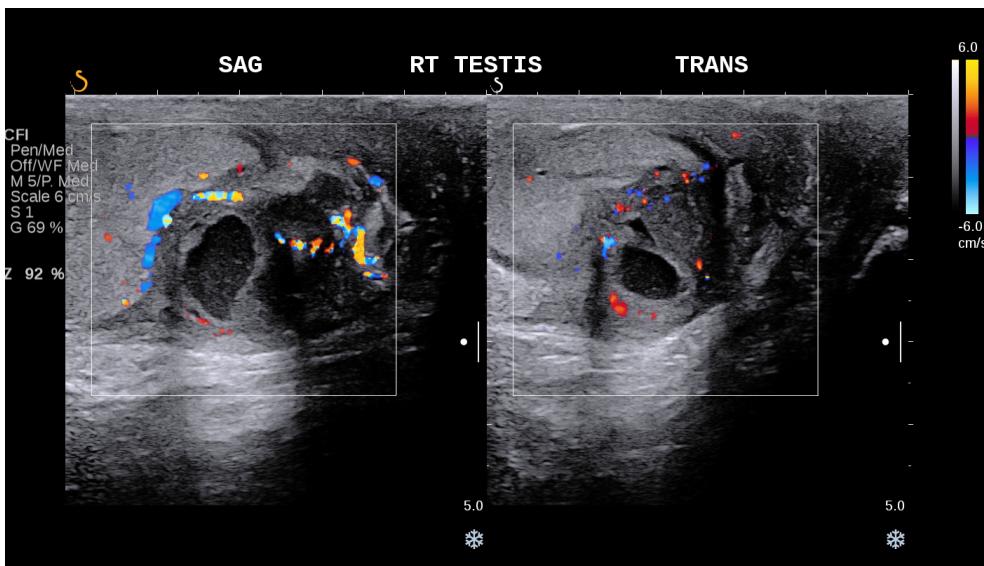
Orchitis with associated abscess formation. Orchitis is associated with a wide range of sonographic findings, as its appearance evolves over time. Initially, there is edema, and the testicle is diffusely hypoechoic. Over time, the edema consolidates, and the hypoechoic areas become patchy. Occasionally, an abscess may develop as pictured here.
